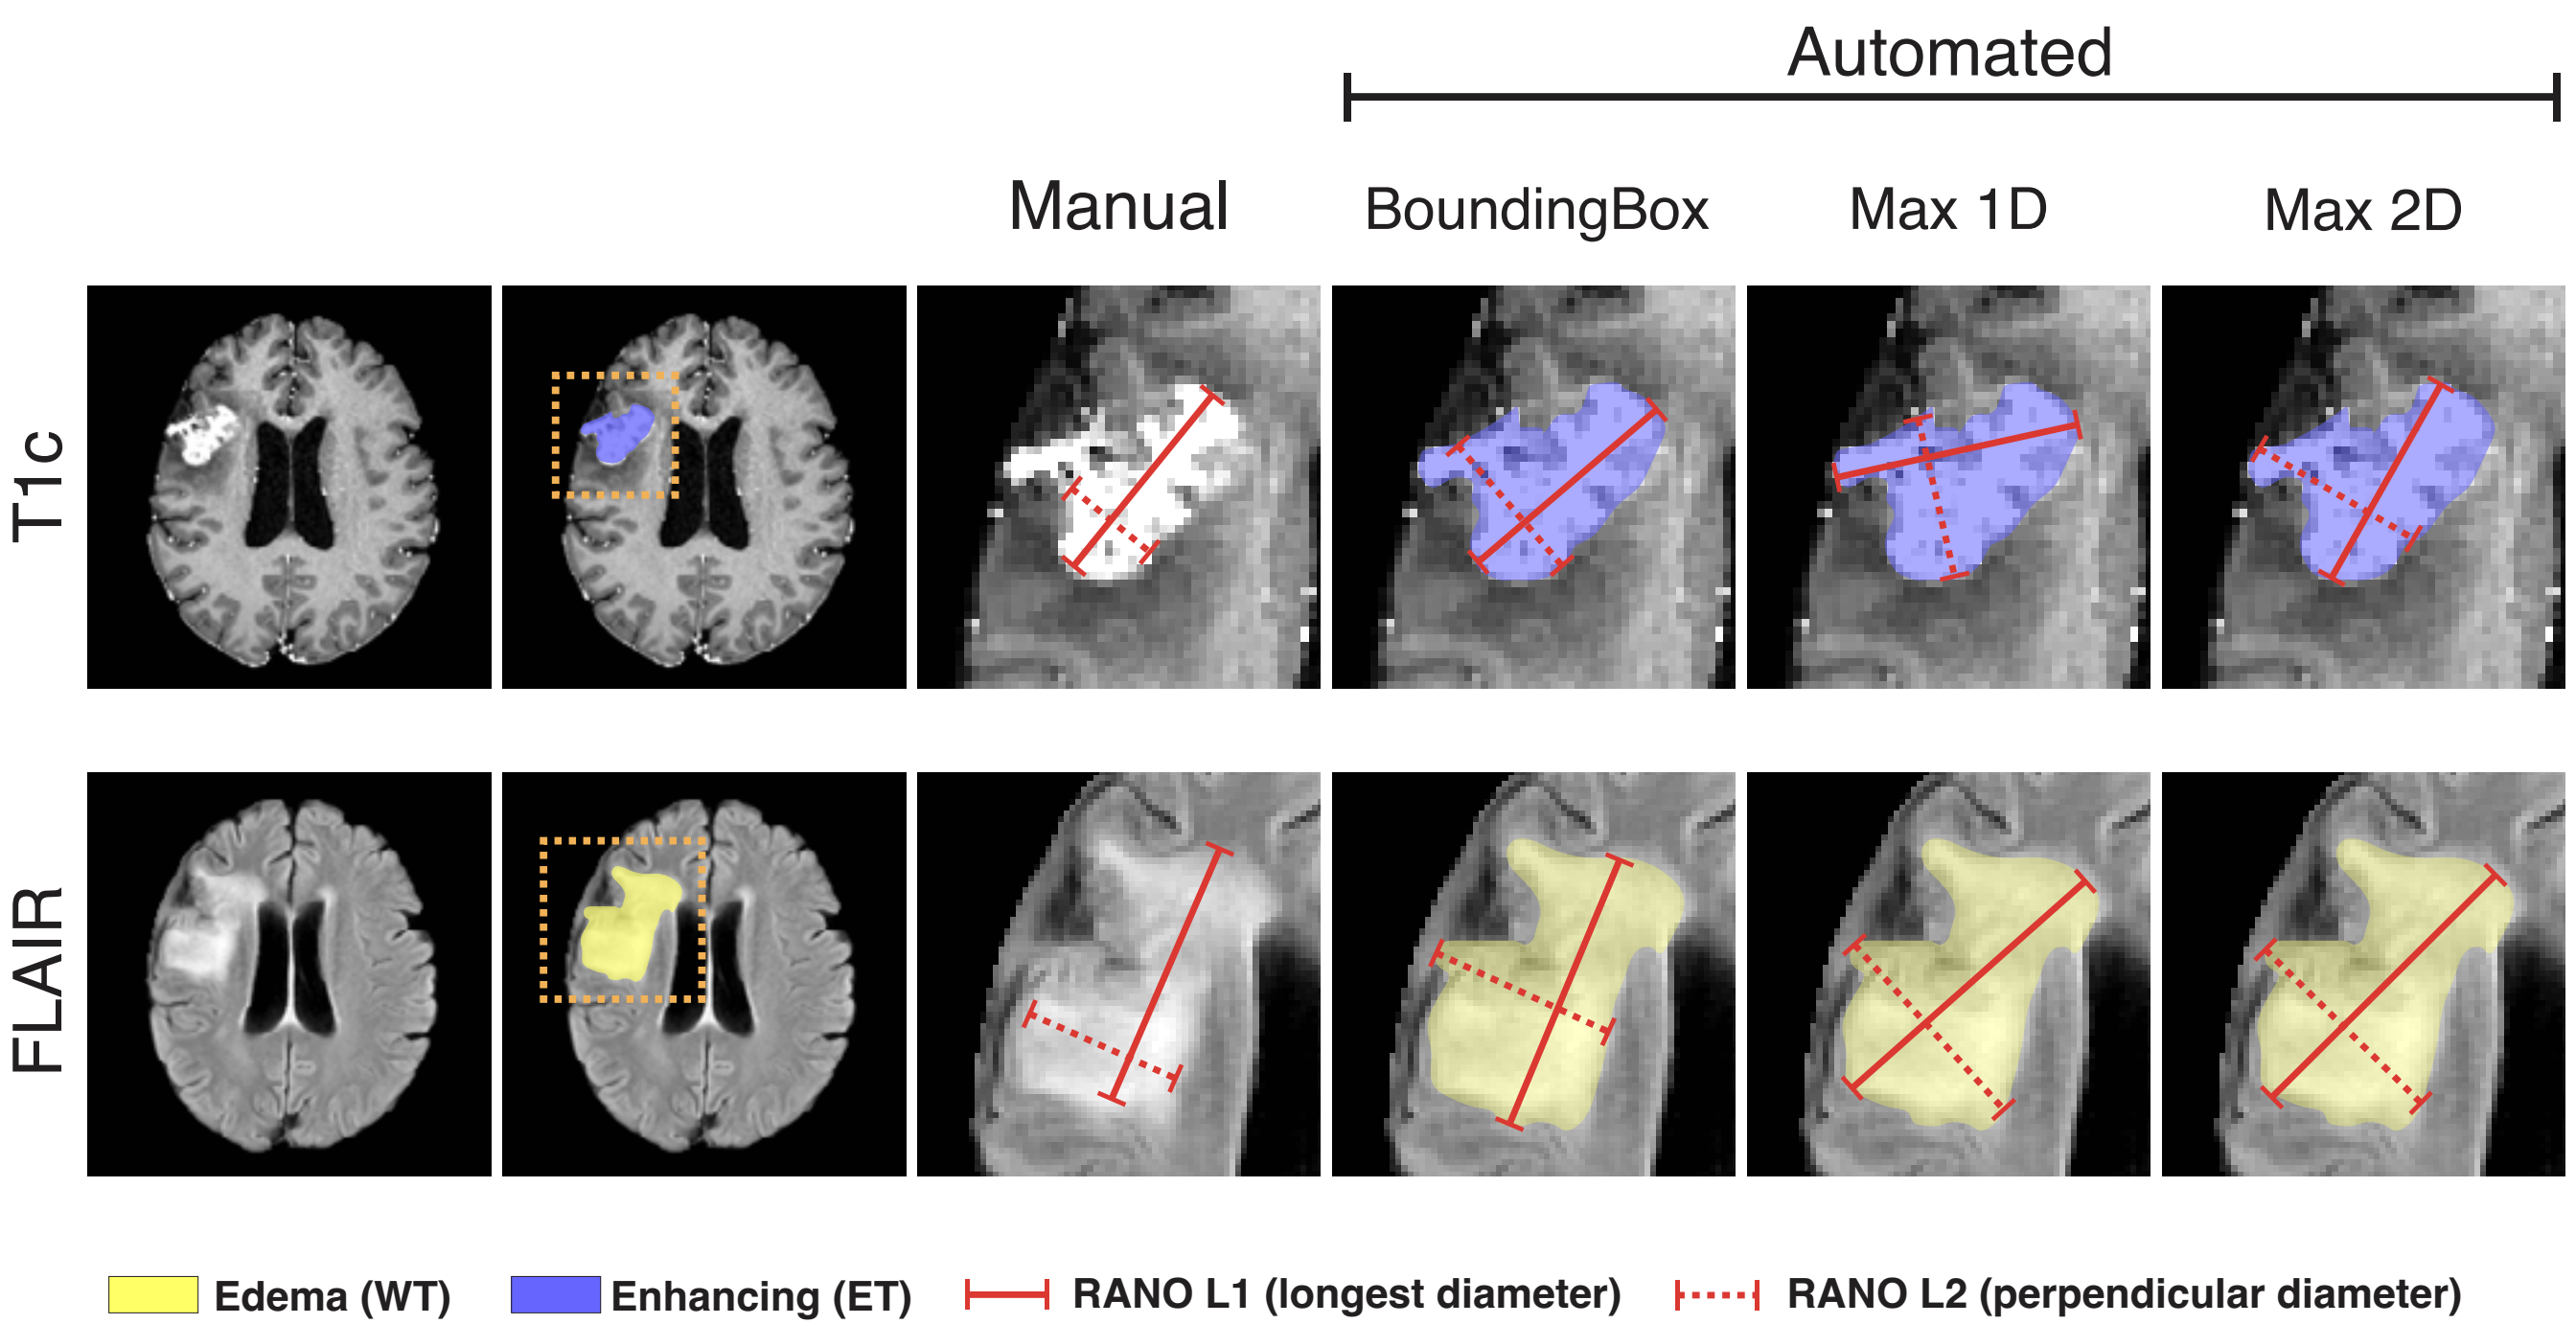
Representative T1c and FLAIR MRI images of Subject 1 from Fig. 1 comparing the RANO L1 (longest diameter) and L2 (perpendicular diameter) bidimensional measurements assessed using the manual, BoundingBox, Max1D, and Max2D methods using the WT and ET subregions.
